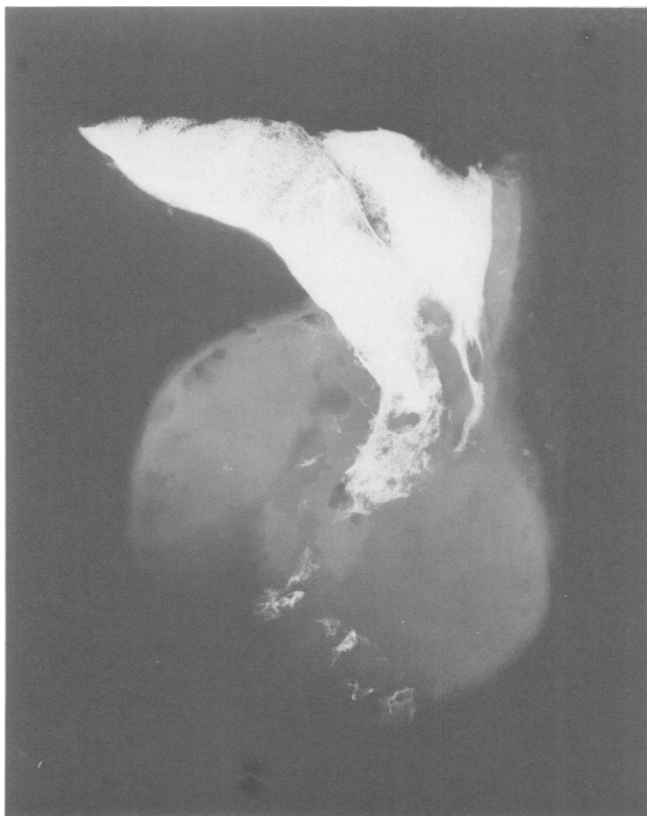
X-ray study of the resected chordoma showing a wide margin of sacrum and widening, destruction and trabeculation of bone.
